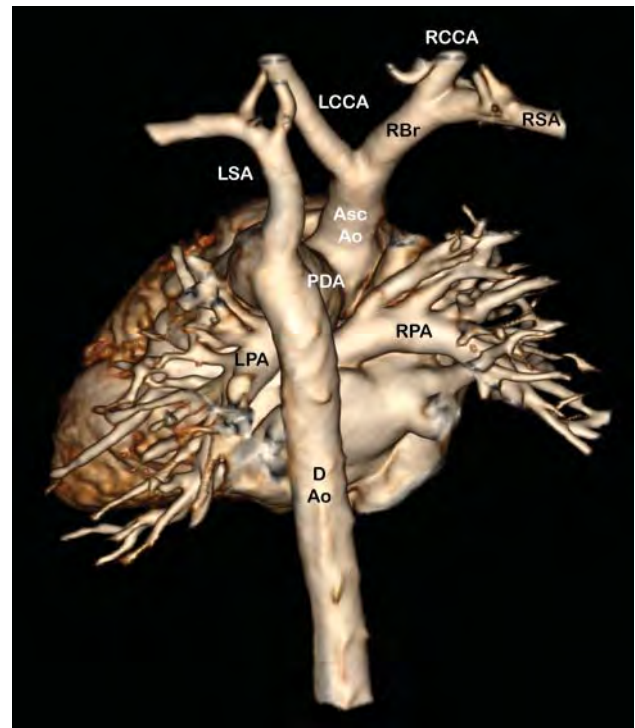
Computed tomographic reconstruction (posterior view) of type B interrupted aortic arch demonstrating origin of descending aorta from patent ductus arteriosus. RBr, right brachiocephalic artery; RPA, right pulmonary artery.
